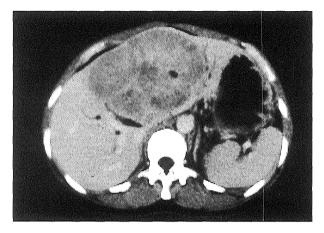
Abdominal CT scan revealed a large low density area $(14 \times 12 \text{ cm})$ in segment IV of the liver.
